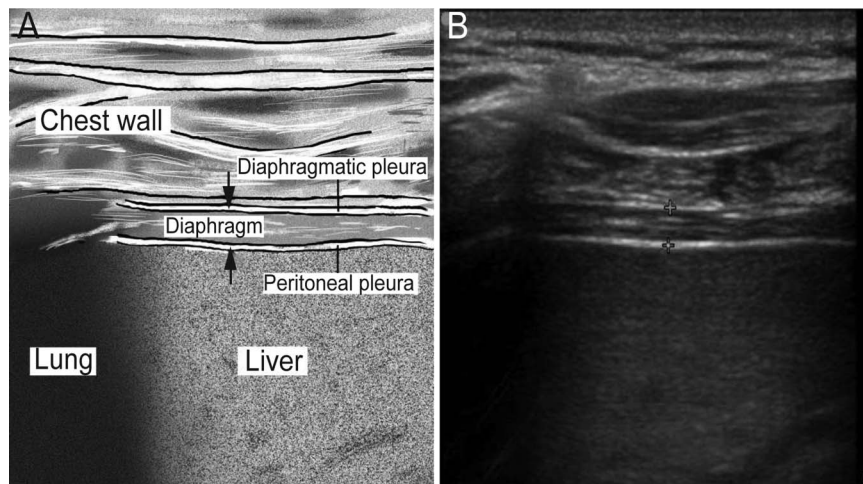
Ultrasonography image of the right hemidiaphragm obtained in zone of apposition with (A) and without labeling (B). The diaphragm can be identified as a 3-layered structure superficial to the liver, consisting of pleural and peritoneal membranes and the muscle itself. In B, crosses indicate the thickness of the diaphragm.
